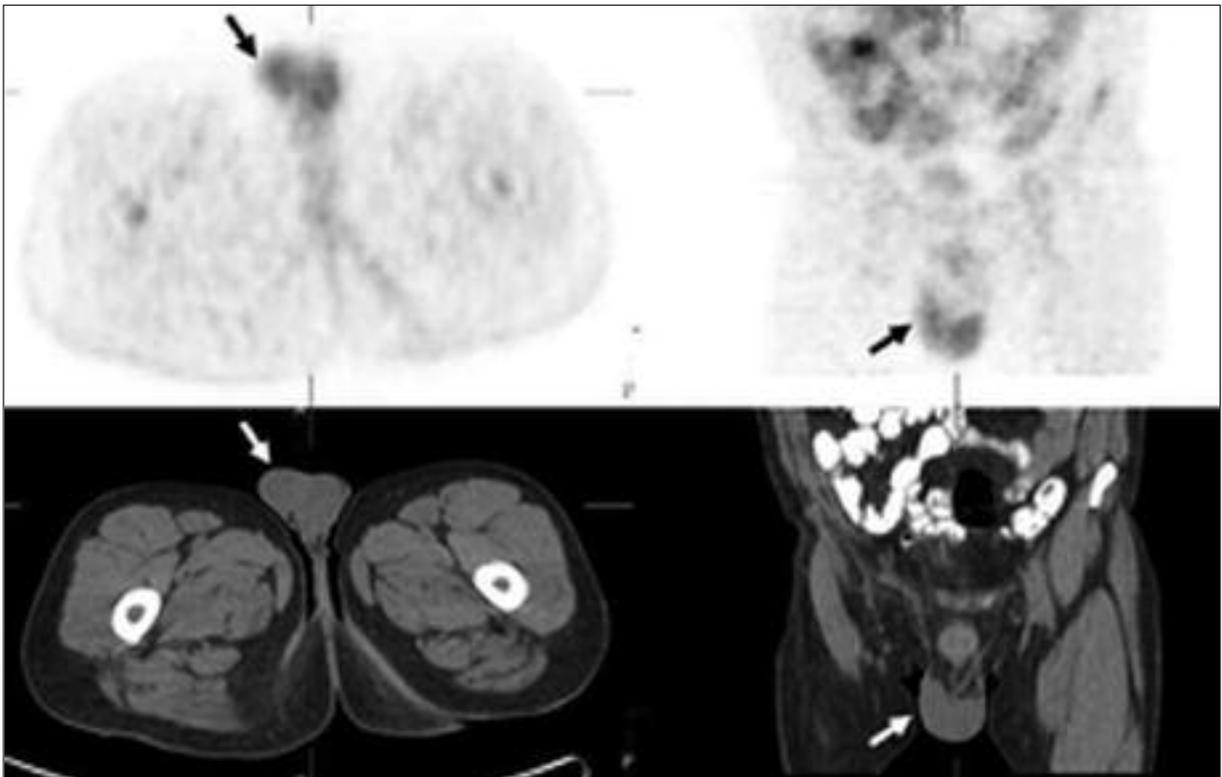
Both testes are in normal localisation at scrotum in the first PET/CT examination.
